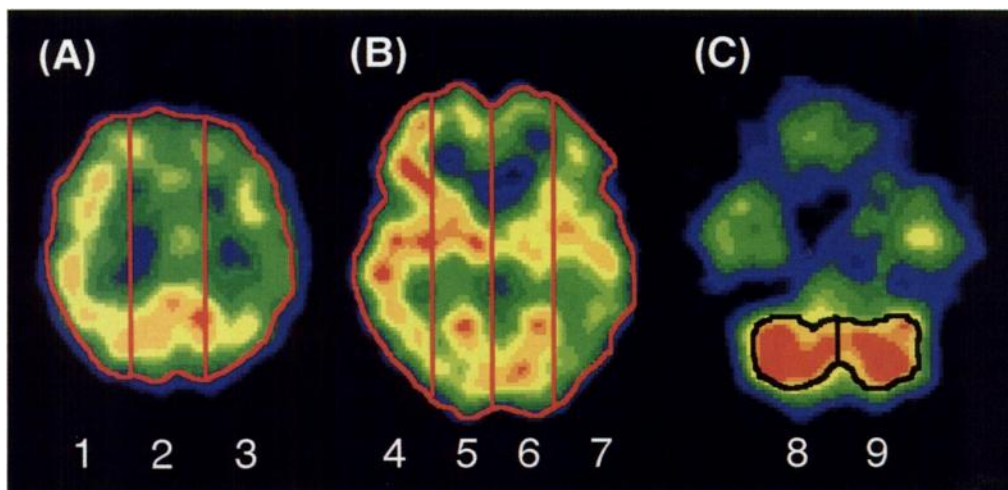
ROI used in the SPECT analysis. Automatically drawn ROIs that correspond to the bilateral MCA territories at the parietal lobe level (1 and 3 in Fig. 1A) and thalamic level (4 and 7 in Fig. 1B), respectively. Manually drawn ROIs corresponding to the cerebellar hemisphere (8 and 9 in Fig. 1C).
